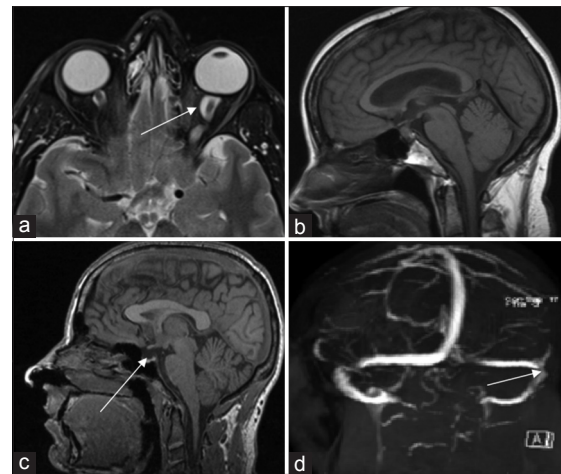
Magnetic resonance imaging highlighting the features associated with idiopathic intracranial hypertension. (a) Note the posterior globe flattening and widened perioptic space, most prominent on the left (arrow). (b) A patient without papilledema and a normal pituitary gland. (c) A partially empty sella (arrow) in a patient with idiopathic intracranial hypertension. (d) Venography demonstrating transverse sinus stenosis at the junction of the transverse and sigmoid sinuses (arrow)
